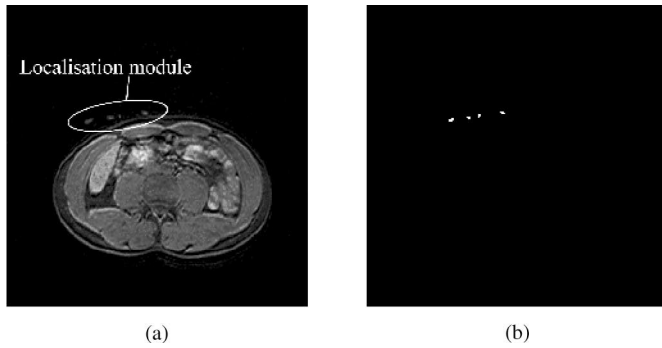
Localization module segmentation from MR images. (a) MR image acquired during *in vivo* experiment on a healthy volunteer's abdomen: the LPR structure generates no signal, only the patient's abdomen and the localization module are visible. (b) Thresholding step extracts parts from the localization module from the rest of the patient's abdomen. Geometric criteria succeed in selecting only parts from the localization module.
